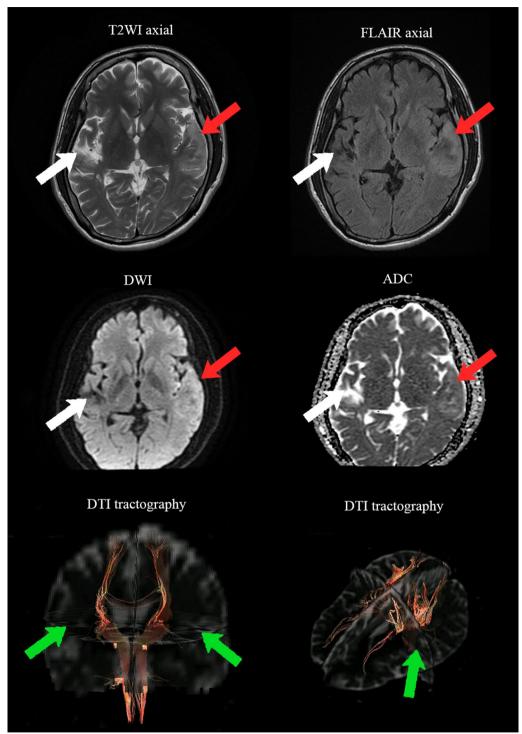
Brain imaging of cortical deafness in recurrent stroke. Brain MRI showed multiple subacute infarctions in the left anterior and posterior temporal lobe (red arrow), multiple chronic infarctions in the right anterior temporal lobe (white arrow), and focal brain atrophy of the right temporal lobe (white arrow). DTI tractography showed no visible tract from bilateral auditory thalamus towards auditory cortices (green arrow). T2WI, T2 weighted image; FLAIR, Fluid Attenuated Inversion Recovery; DWI, Diffusion-Weighted Imaging; ADC, Apparent Diffusion Coefficient; DTI, Diffusion Tensor Imaging
